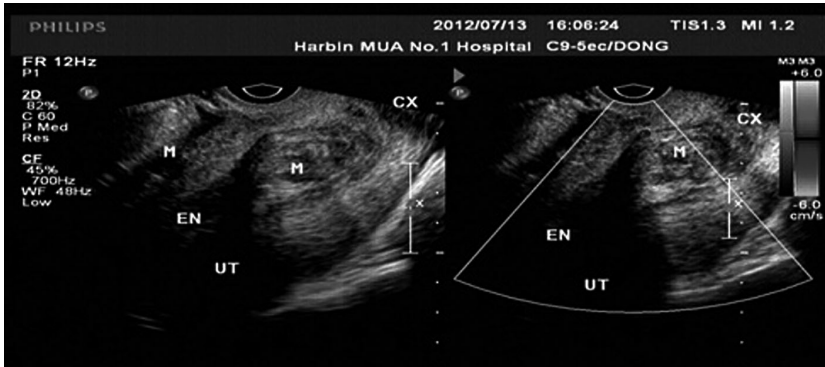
Submucosal uterine fibroids by transvaginal ultrasound and color Doppler flow imaging.
